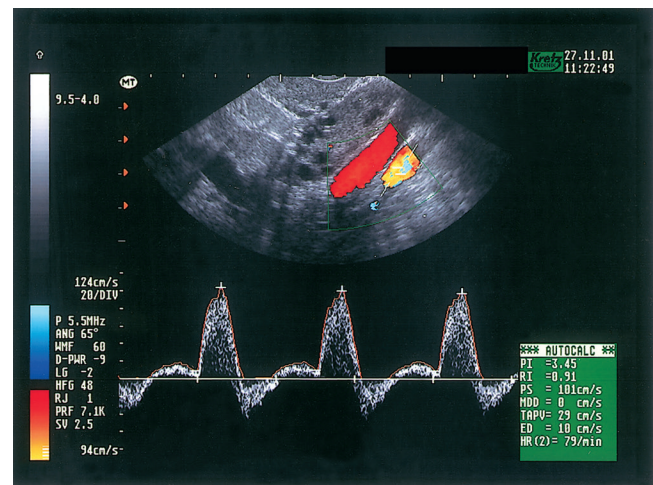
Typical color Doppler ultrasound of a polycystic ovary showing increased blood flow.
